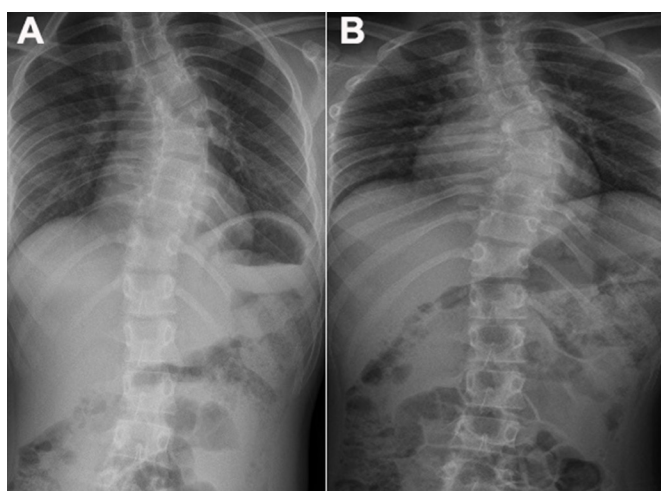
(A) Standing anteroposterior radiograph of the spine showing a severe right thoracic scoliosis. (B) A supine stretch film of the same patient without significant correction, indicating the rigidity of the curve.
